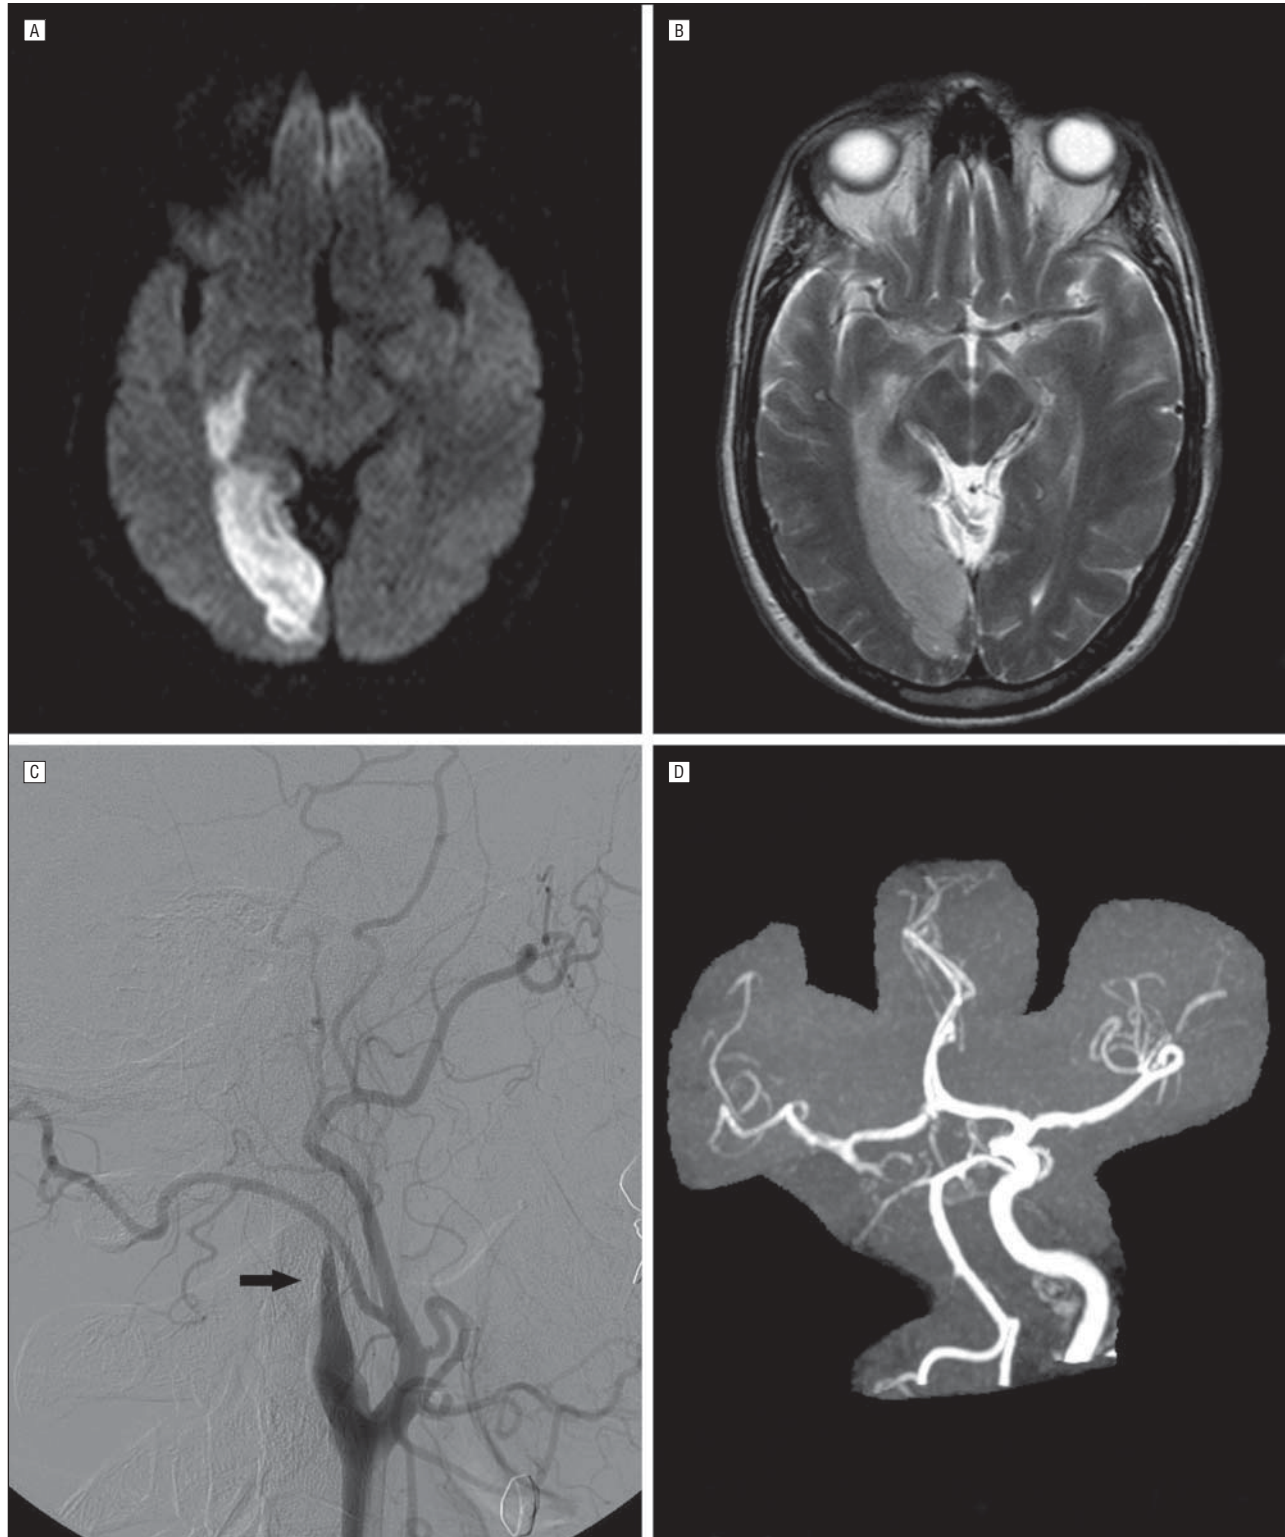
Magnetic resonance imaging (MRI), digital subtraction angiography, and magnetic resonance angiogram of a 45-year-old man with isolated posterior cerebral artery (PCA) infarction caused by carotid artery dissection. Right PCA infarct is demonstrated by MRI (diffusion-weighted imaging [A] and T2-weighted sequences [B]). Digital subtraction angiography shows a tapered occlusion of the right internal carotid artery (ICA) compatible with dissection (C, arrow). D, Magnetic resonance angiogram reveals an asymmetry of the proximal portion (P1) of the PCAs, with a hypoplastic right P1, suggesting that the right occipital lobe was originally supplied by the right ICA.
